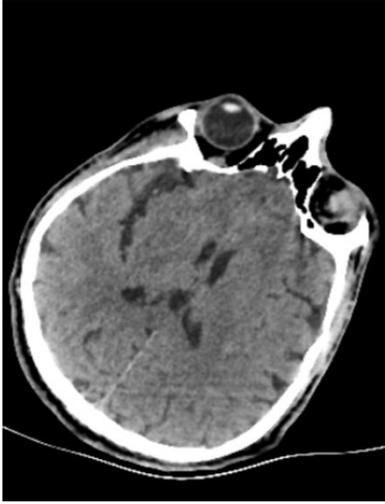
The patient's non-contrast cranial computed tomography image
